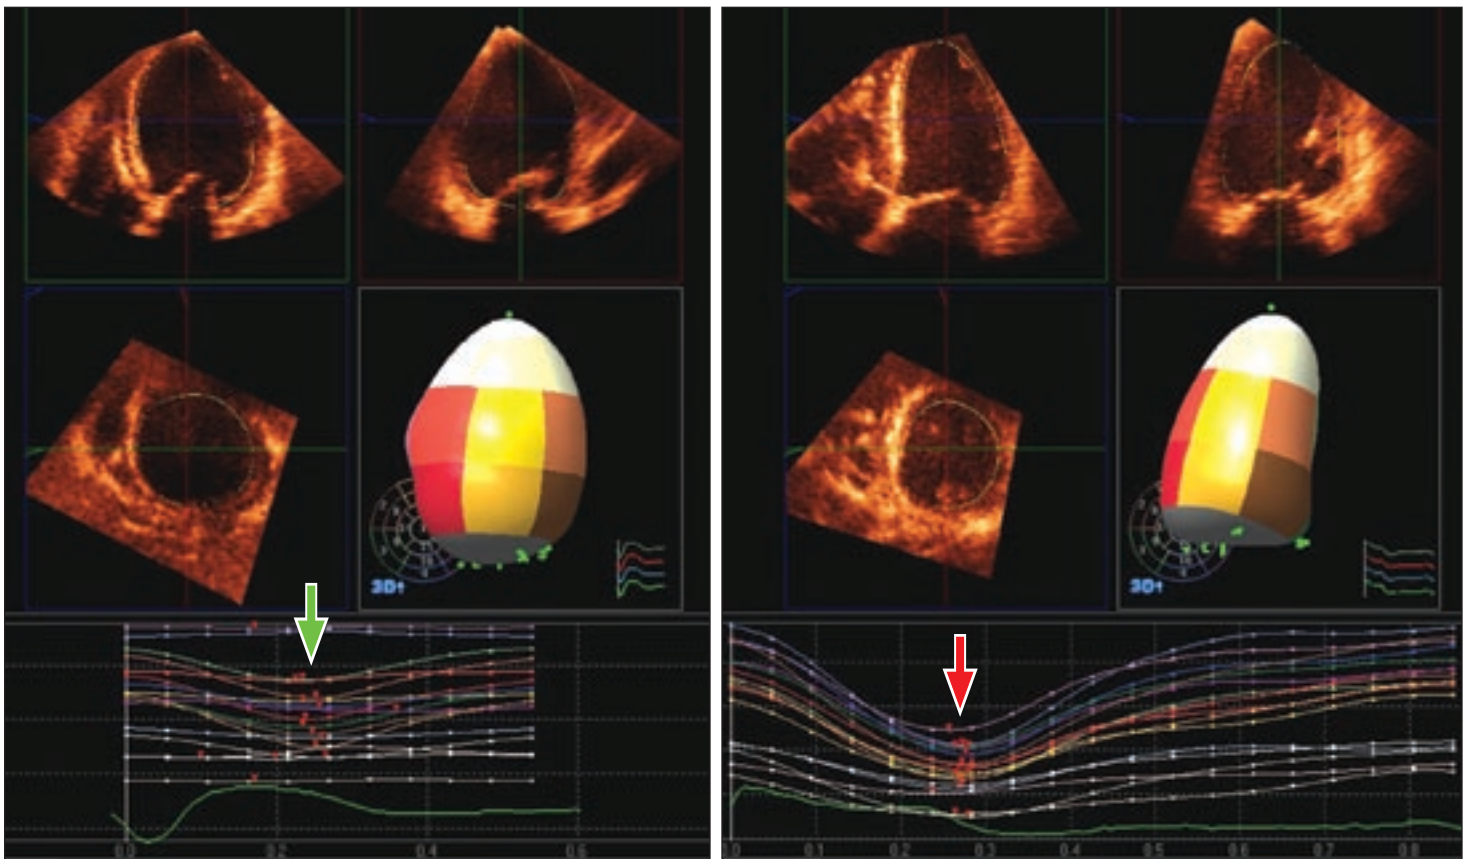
3D Echocardiography for Left Ventricular Dyssynchrony. Segmental volume curves before (left) and 12 months after (right) cardiac resynchronization therapy (CRT) in an 81-year-old woman with nonischemic dilated cardiomyopathy who underwent the upgrade from a dual-chamber pacemaker to a biventricular pacemaker. The standard deviation in time to minimal volume in 16 segments improved from 8.1% (green arrow) to 1.1% (red arrow) after CRT. This patient showed considerable reverse remodeling at 12 months after CRT (end-systolic volume, 197 mL to 47 mL; end-diastolic volume, 226 mL to 104 mL) (image courtesy of Chinami Miyazaki, MD).
